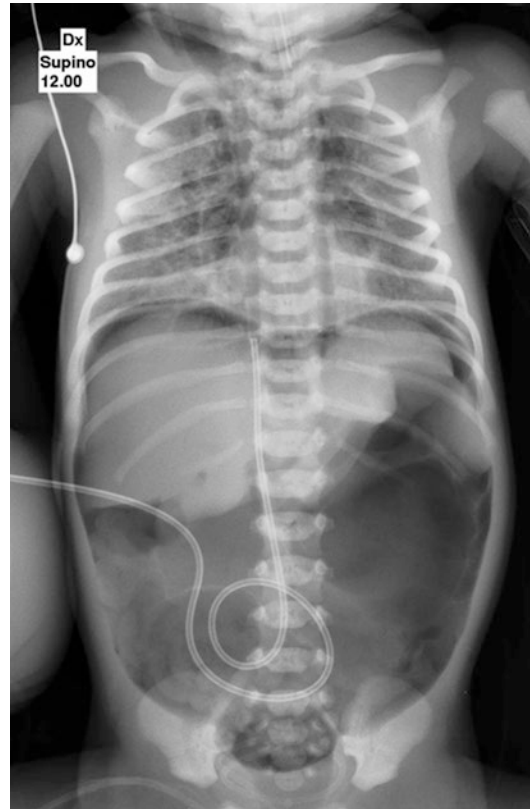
X-ray study: preterm baby with pneumoperitoneum after high-pressure ventilation. The laparotomy excluded a perforation of the viscera
